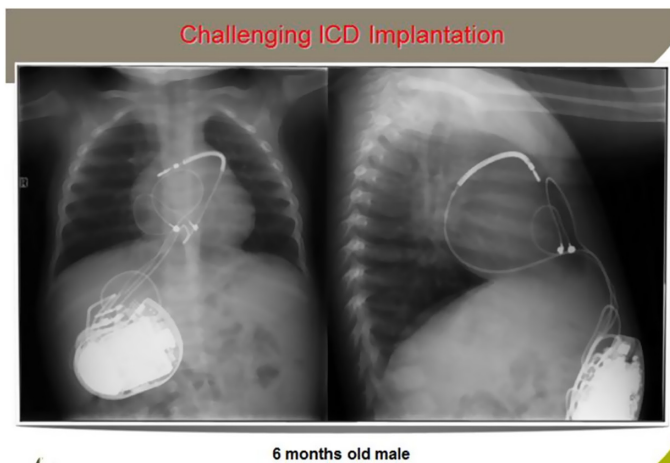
Thorax x-ray of the abdominal implantation of a defibrillator (ICD) in a 6-month-old baby. The shock lead is located in the sinus transversus with the distal electrode screw in the right atrium. Two epicardial electrodes are placed for sensing and pacing in the right ventricular free wall. The system is completely extravascular with all the benefits of a DDD ICD. Discrimination algorithms, DDD sensing, and pacing and antitachycardia pacing are in contrast with the subcutaneous ICD fully available.
